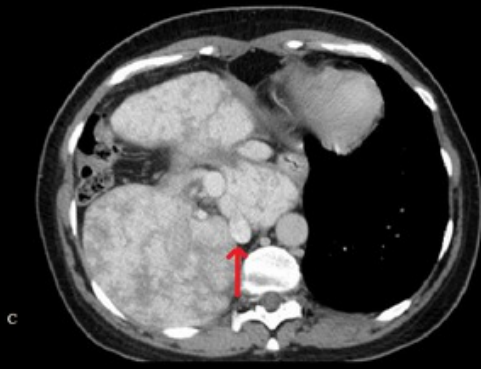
Hepatic herniation secondary Budd-Chiari: Axial and coronal enhanced computed tomography show a chronic Budd-Chiari, with patchy enhancement areas (portal venous phase - figures B-F) and regenerative nodules (hypervascular in arterial phase - figure A). IVC is compressed by the abnormal intrathoracic hepatic location, without thrombosis.
